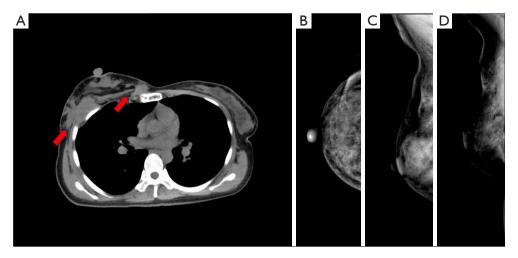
The CT and X-ray images of desmoid-type fibromatosis in the breast (the red arrows mark the location of the mass in case 1). (A) The CT scan demonstrated multiple irregular soft tissue masses with indistinct margins in the posterior chest wall of the right breast. (B-D) X-ray revealed distortion and retraction of the skin in the upper outer quadrant of the right breast, which was accompanied by disorganized structures in the posterior gap. CT, computed tomography.
